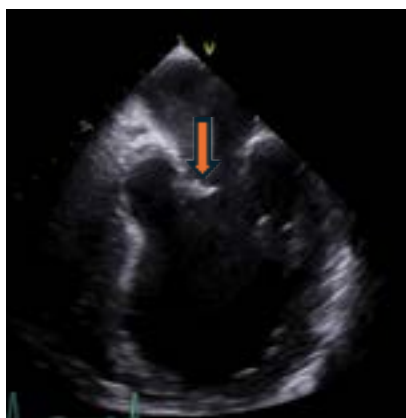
Echocardiography showing a large (1.0 x 0.4 cm) mitral valve vegetation (arrows).
